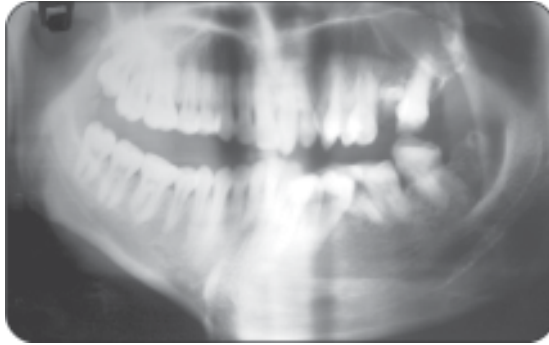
Radiograph of facial hemihypertrophy
